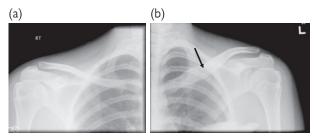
Plain radiographs of (a) right and (b) left clavicle. Left clavicle shows cortical expansion and sclerosis (arrow).
